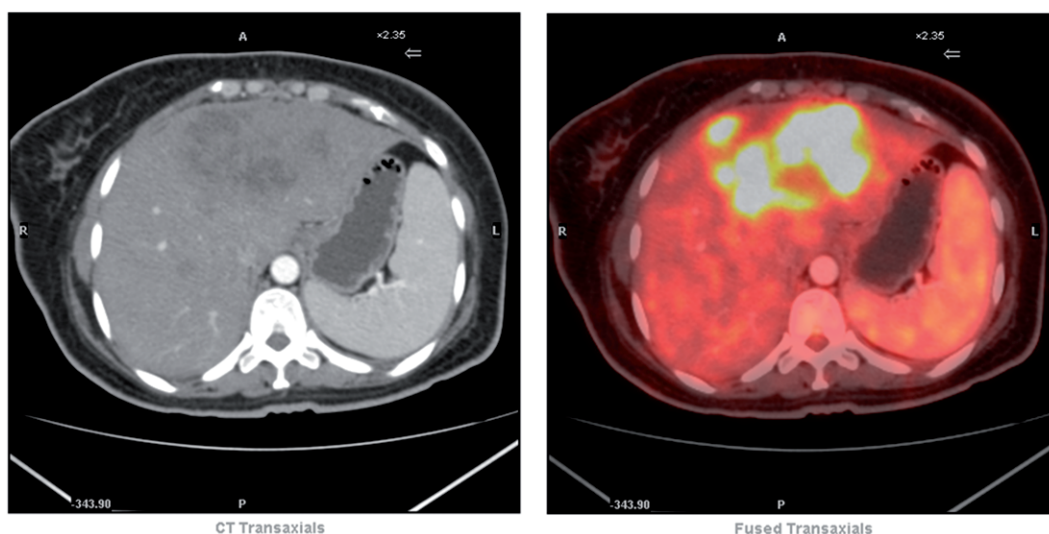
Staging [¹⁸F]FDG-PET/CT revealed a large irregular hypodense lesion involving predominantly the left lobe of the liver measuring 10 × 8 × 9 cm in size (left panel) with intense heterogeneous FDG uptake of $SUV_{max}=37.1$ (right panel).
